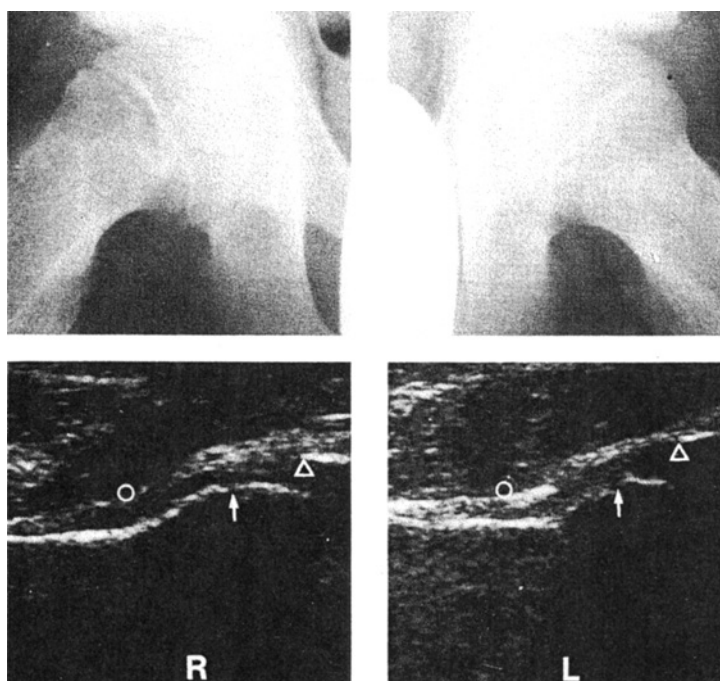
Anterior ultrasonograms and frog-leg lateral radiographs of a 13-year-old boy, with labels as in Figure 1. The radiograph shows a minimal physeal slip of the right hip (R). No slip is seen on the sonogram, but the metaphysis appears somewhat less prominent than on the left side because of metaphyseal remodeling.
